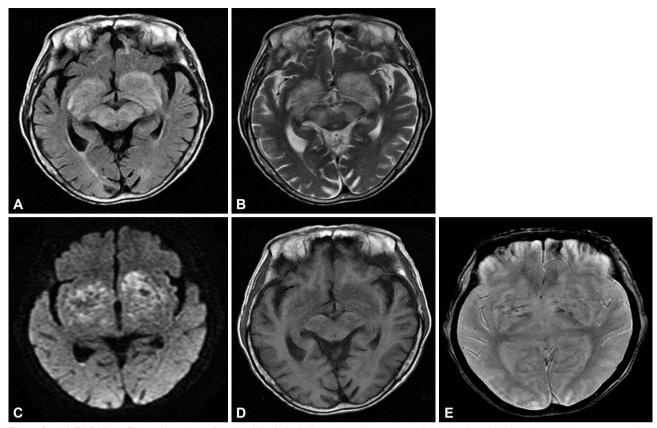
Brain MRI findings. Bilateral basal ganglia and midbrain including red nucleus, crus cerebri, and substantia nigra showed almost symmetrical lesions with hyperintensities in fluid-attenuated inversion recovery (A), T2-weighted image (B), diffusion-weighted image (C), and hypointensities in T1-weighted image (D). Gradient echo (E) showed low signal lesions suggesting petechial hemorrhage in bilateral basal ganglia.
